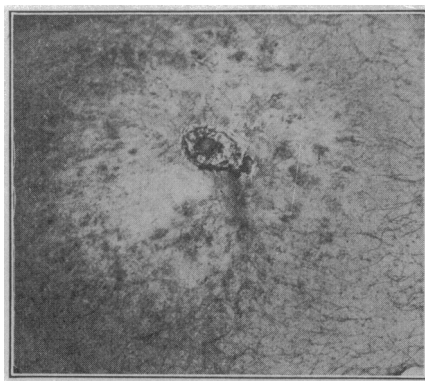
Epithelioma of the umbilicus emanating from an extensive atrophic scar following severe Roentgen-ray burn.
